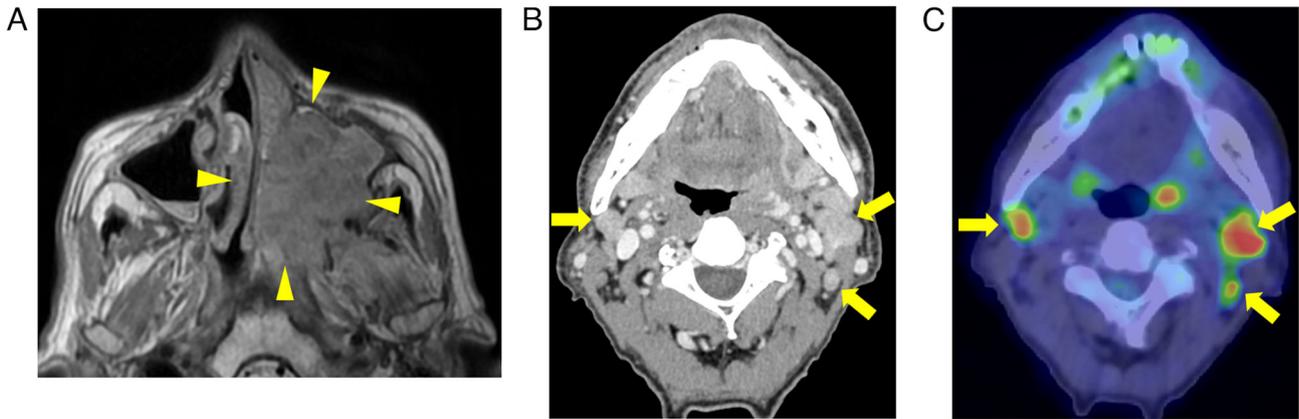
Various imaging findings before treatment. (A) Magnetic resonance imaging showed a tumor that filled the ethmoid and maxillary sinuses and destroyed the pterygoid process. The arrowheads point to the tumor. (B) Contrast-enhanced computed tomography and (C) 18-fluoro-2-deoxyglucose positron emission tomography showed multiple enlarged lymph node metastases in the bilateral cervical regions. The arrows indicate metastatic nodes.
